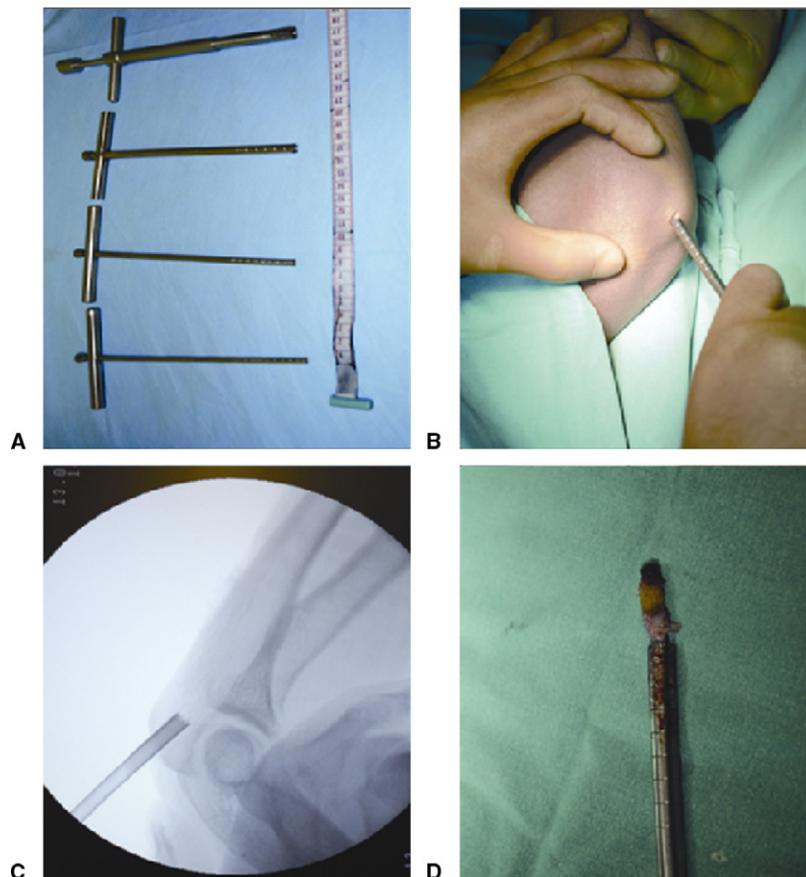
A Different-sized bone biopsy trephines. B Insertion of trephine via an incision over olecranon. C Intraoperative radiographic view of the trephine in the olecranon. D Harvested bone graft.
